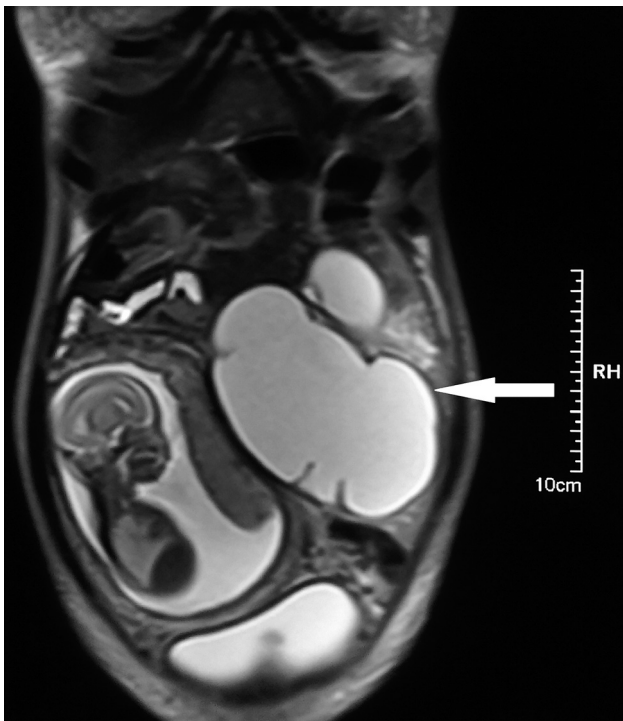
MRI Showing giant hydronephrotic left kidney with thin rim of renal parenchyma and 24 weeks foetus on the right side.
